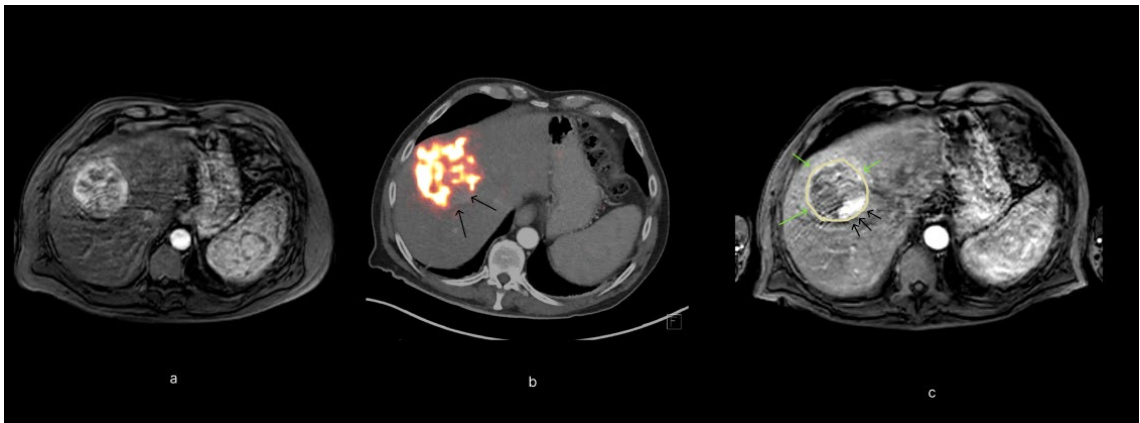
Example of patient with heterogenous microsphere distribution and heterogenous response to the treatment. a) The baseline image (MRI) demonstrated hepatocellular carcinoma as an enhancement; b) On the PET/CT following treatment, black arrows show a part of the tumor that didn't receive microspheres; c) Tumor on MRI shows a heterogenous response to the treatment; this part uses green arrows to show how this part of the tumor responded to the treatment, meaning part of the tumor is dead (necrotic) while the other part of the tumor is still viable (black arrows).
